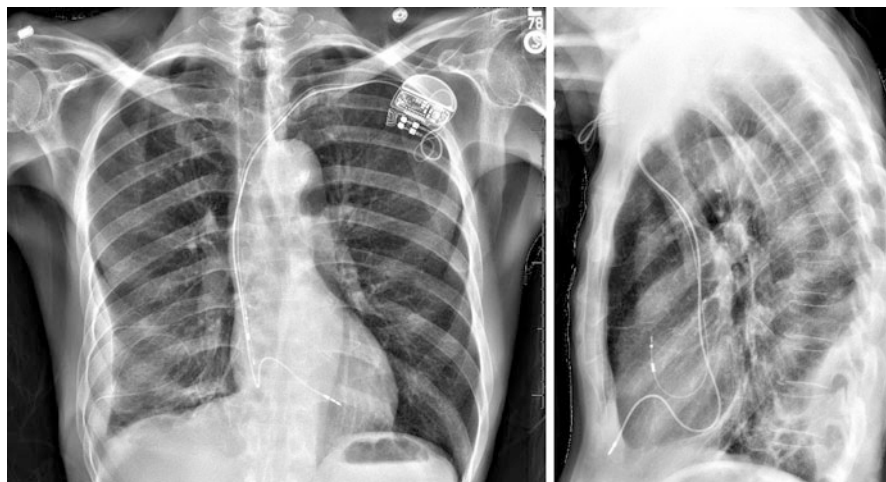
Chest radiograph PA and lateral of a patient with dual chamber pacemaker
